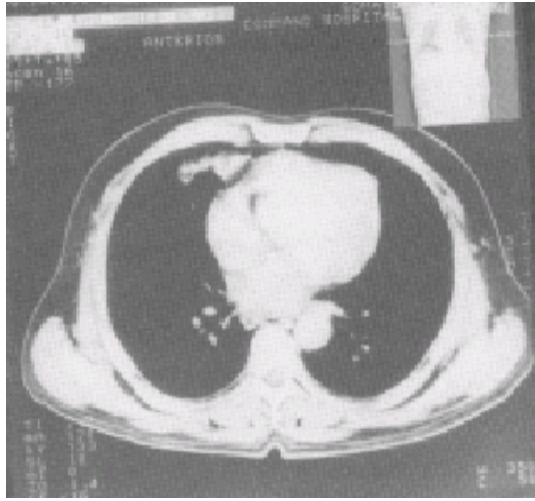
CT scans of thorax, both mediastinal and lung window revealing anteriorly located pleural-based opacity with bronchovascular markings converging to it.
